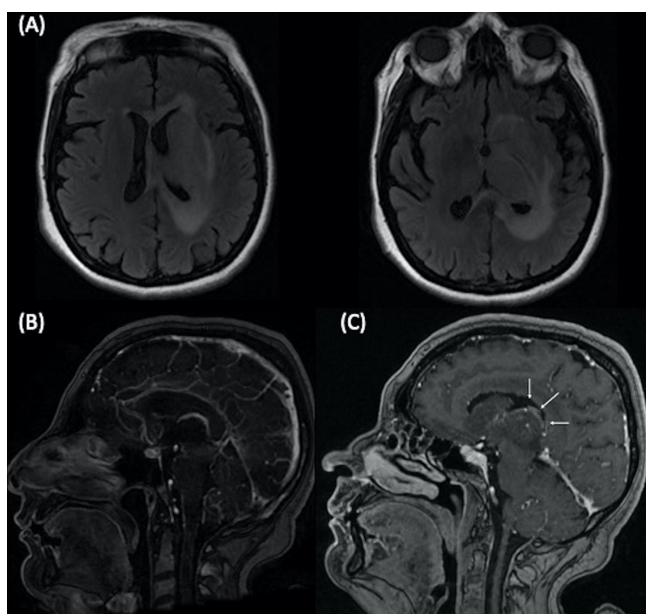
Axial FLAIR showing left vasogenic edema, including the deep grey and white matters (A), Parasagittal postcontrast T1-weighted MR images: normal right deep cerebral vein (B) abnormal opacification of left deep cerebral vein (C).
